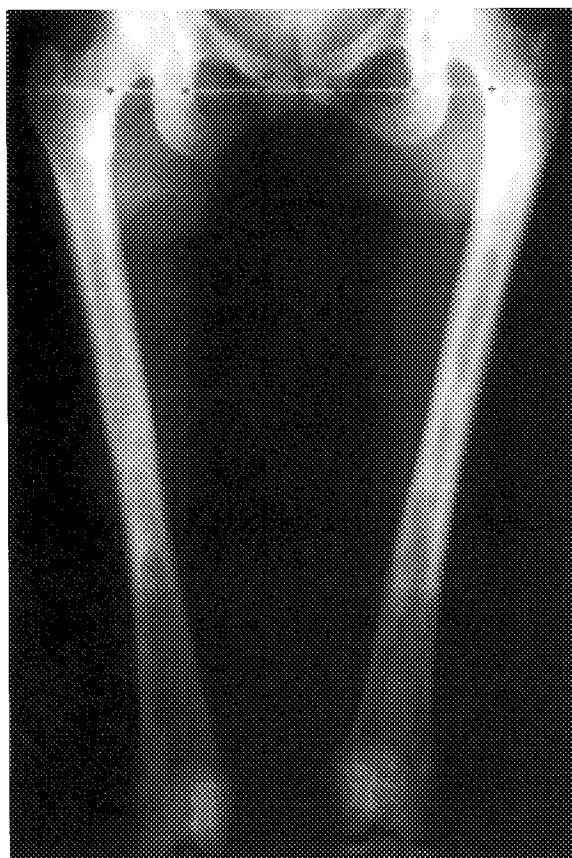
Radiograph of both femurs. Hypertrophic bone, mixed radio-lucent and radioopaque lesions, cortical thinning (distal third) or hypertrophy, and disappearance of the bone structure.
